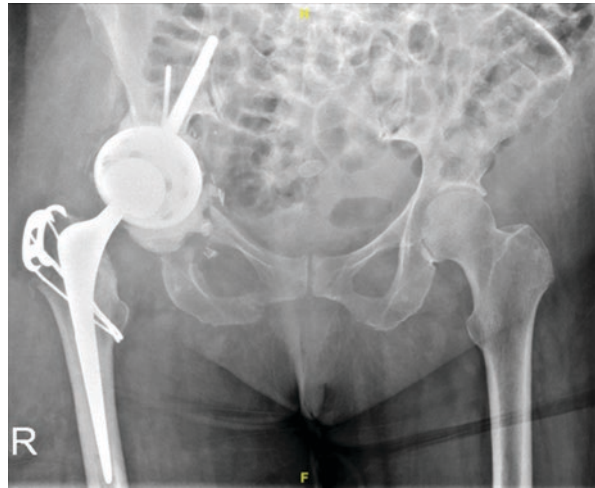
(a) CT scan demonstrating left periacetabular chondrosarcoma. (b) Type I–II resection and reconstructed with bespoke 3D printed implant
